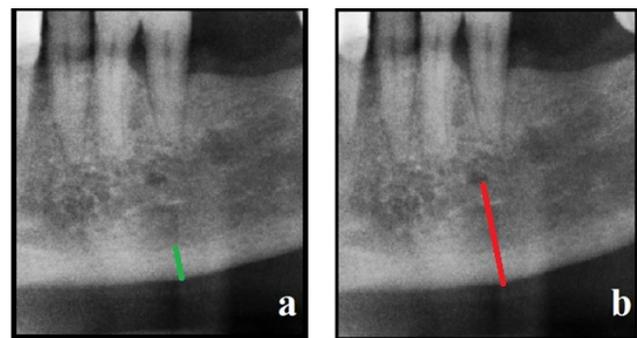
BMH (a) and MFH (b) measurements of a patient with osteoporosis on panoramic radiographs.
